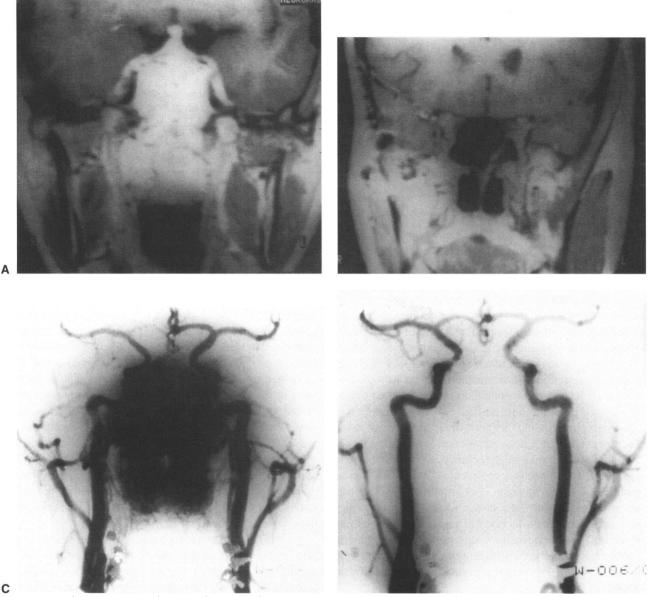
Nasopharyngeal paraganglioma (case 5). A. Preoperative coronal MRI showing tumor invasion of the sphenoid sinus and displacement of the right internal carotid artery close to the cavernous sinus. B. Postoperative (8 months) coronal MRI showing tumor removal and occlusion of right internal carotid artery (→). C. Preoperative angiogram showing extent of tumor. D. Angiogram after embolization.
